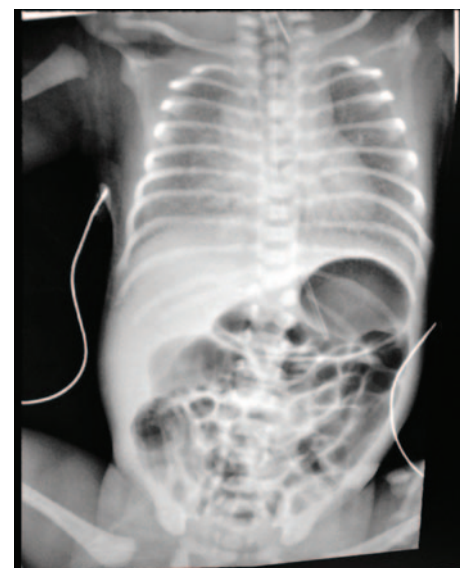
A chest and abdominal X-ray showing a high endotracheal tube and dilated bowel loops.
